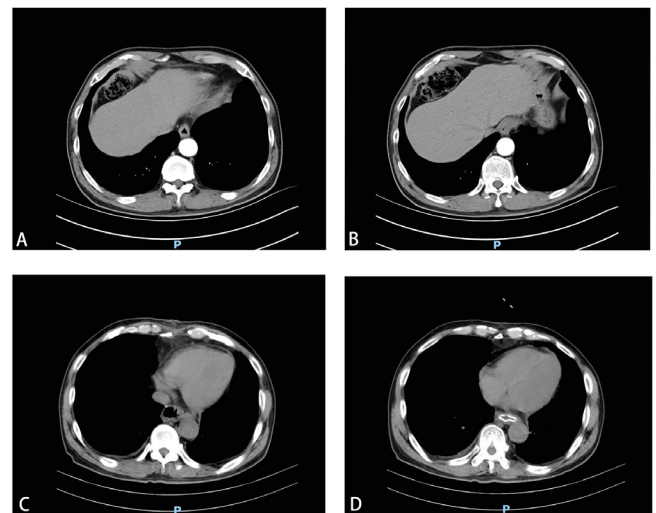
Preoperative and postoperative thoracoabdominal CT scans of the patient who underwent laparoscopic total gastrectomy.
